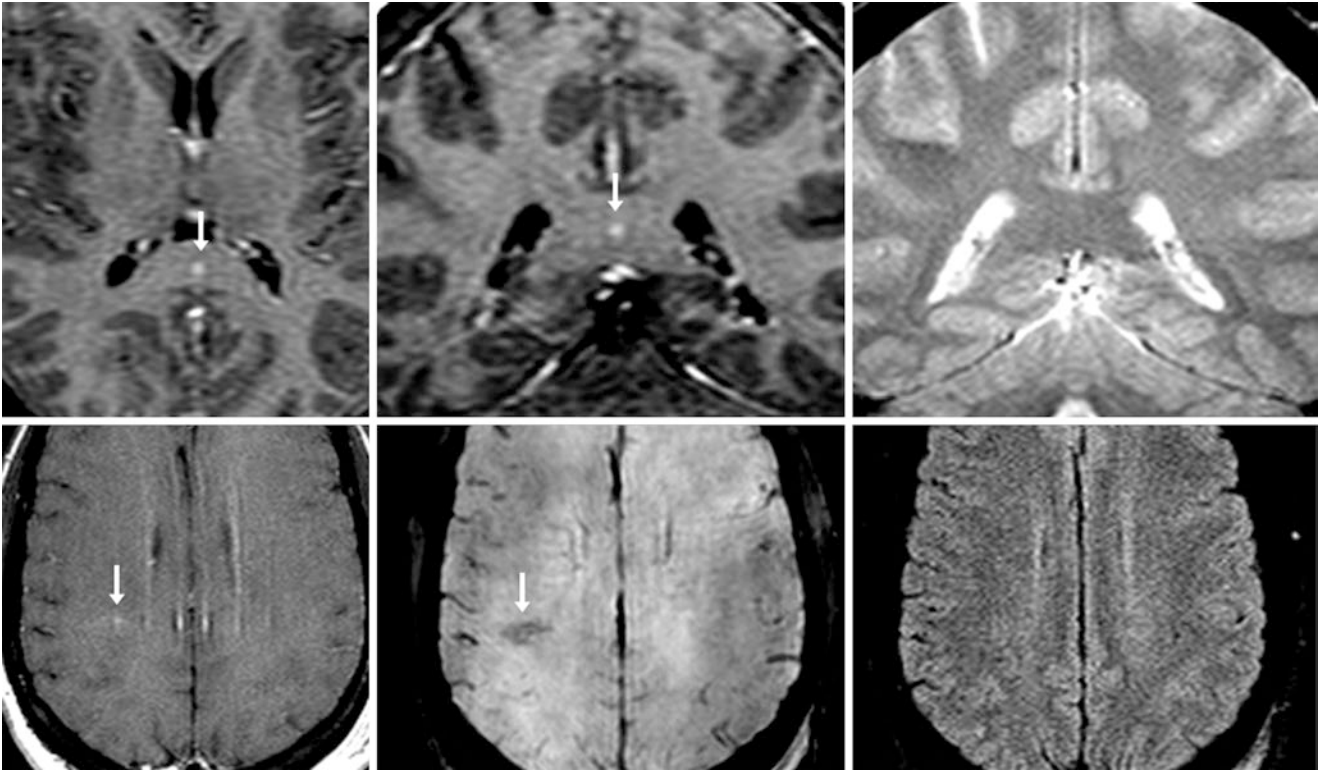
A 42-year-old post-trauma patient with two BCTs. On a 1.5T brain MRI, postcontrast axial (*top left*) and coronal (*top middle*) GE T1WIs showed focal enhancement of a BCT within the callosal splenium, while GE T2*WI (*top right*) was normal, indicating this was not a shear
